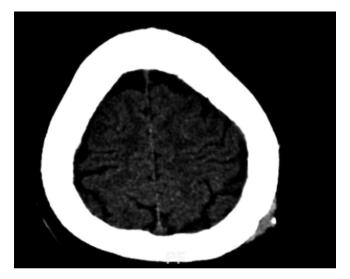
Contrasted CT scan of the head showing the contrast enhancing left parietal scalp lesion with outer cortex skull erosion.
